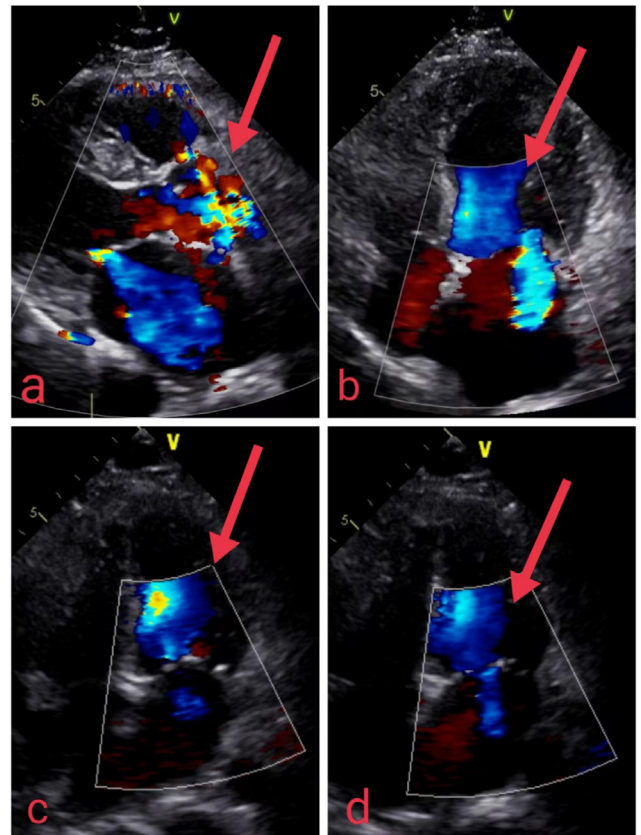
The echocardiogram of a patient treated with CABG. 4A and 4B depicts the preoperative mitral regurgitation status; 4C and 4D portray the degree of mitral regurgitation in patients after CABG. The arrow is pointed to the mitral valve area.
